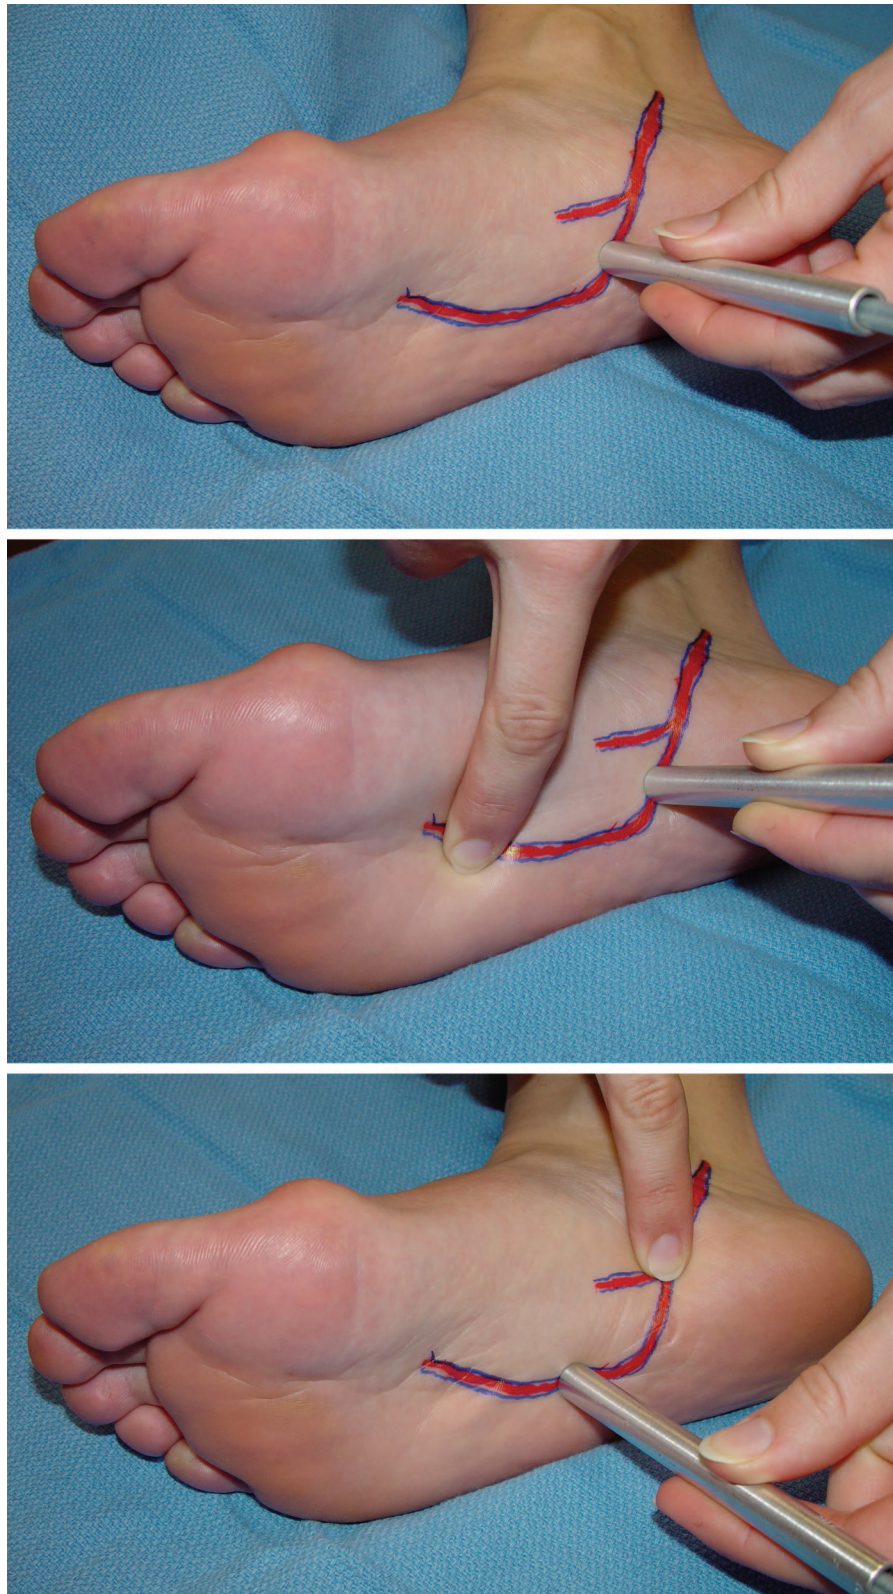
(Above) The lateral plantar artery is identified by Doppler proximal to the base of the proximal first interspace. (Center) The cruate anastomosis is occluded at the level of the tarsal-metatarsal joint. If the sound remains, it means that there is antegrade flow from the distal posterior tibialis artery. (Below) To check for retrograde flow along the lateral plantar artery, the distal posterior tibial artery is occluded before the takeoff of the medial and lateral plantar arteries and the lateral plantar artery is checked by Doppler. If there is a signal, there is retrograde flow.
